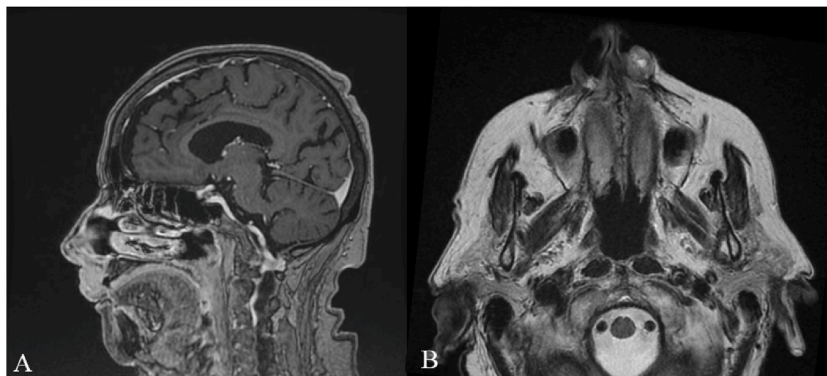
MRI sagittal section (A) and axial section (B). Extension from the upper lip to the left nasal cavity is noticed.
